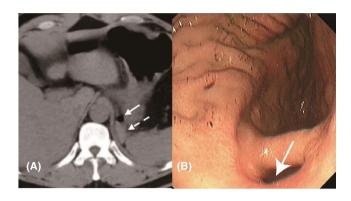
Postoperative examination. (A) Adrenal CT scan 3 days after operation: the solid arrow points to the bubble, and the dashed arrow points to a flattened cystic lesion; (B) gastroscopy performed after operation: the arrow points to the gastric diverticulum.
